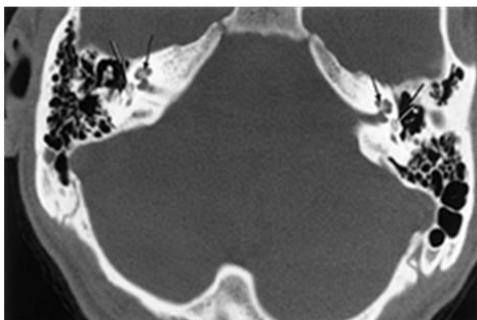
Labyrinth (*meningogenic*) ossification. Temporal axial CT scan section showed clear hardening in the anterior chamber (thick arrow). There was a slight change in ossification at the top of the cochlea (thin arrow)
